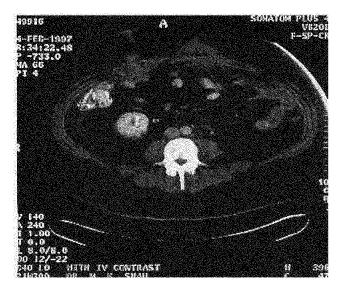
CT scan of the abdomen demonstrating a port-site recurrence.
